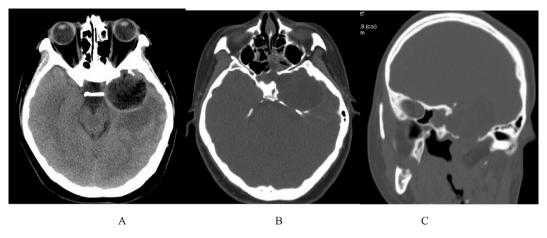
Axial brain CT image showing a round bulging hypoattenuated mass in the left middle cranial fossa and intruding into intracranial parenchyma with ring-like hyper-attenuated thin wall (A). Axial bone window and oblique-coronal reformatted CT images demonstrating remarkable bony defect of left temporal bone with surrounding erosion and sclerosis and communicating with sphenoid sinus and left posterior ethmoid sinus with mucosal thickening (B, C).
